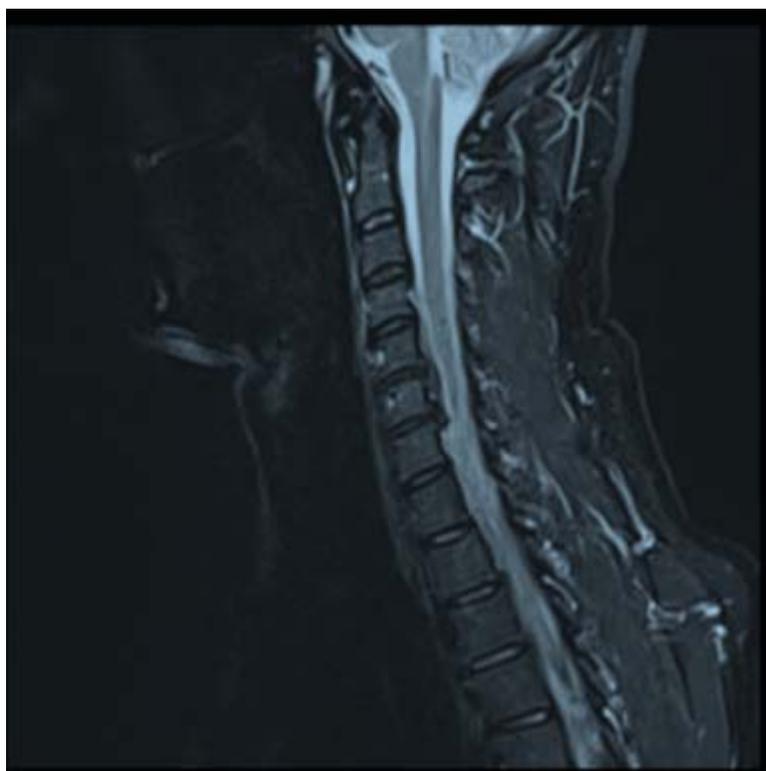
T2 weighted sagittal MRI
